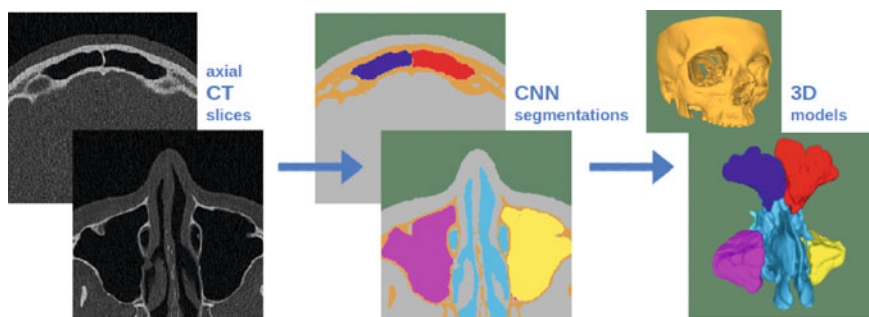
Axial CT slices, the multi-class segmentations computed by a CNN, and the 3D models generated from these
